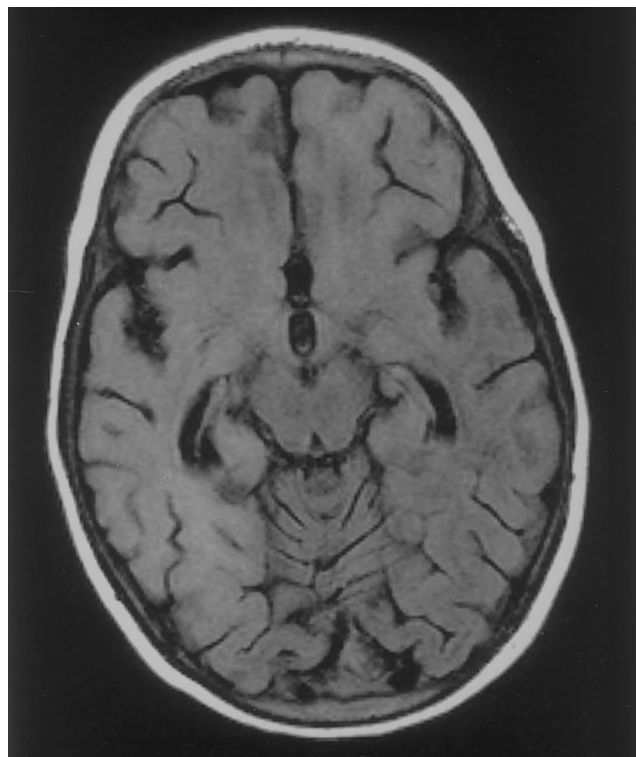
MRI from the brain of a 25-month-old patient with subacute sclerosing panencephalitis, showing increased signal intensity of the complete right hemisphere and the left frontal lobe.
